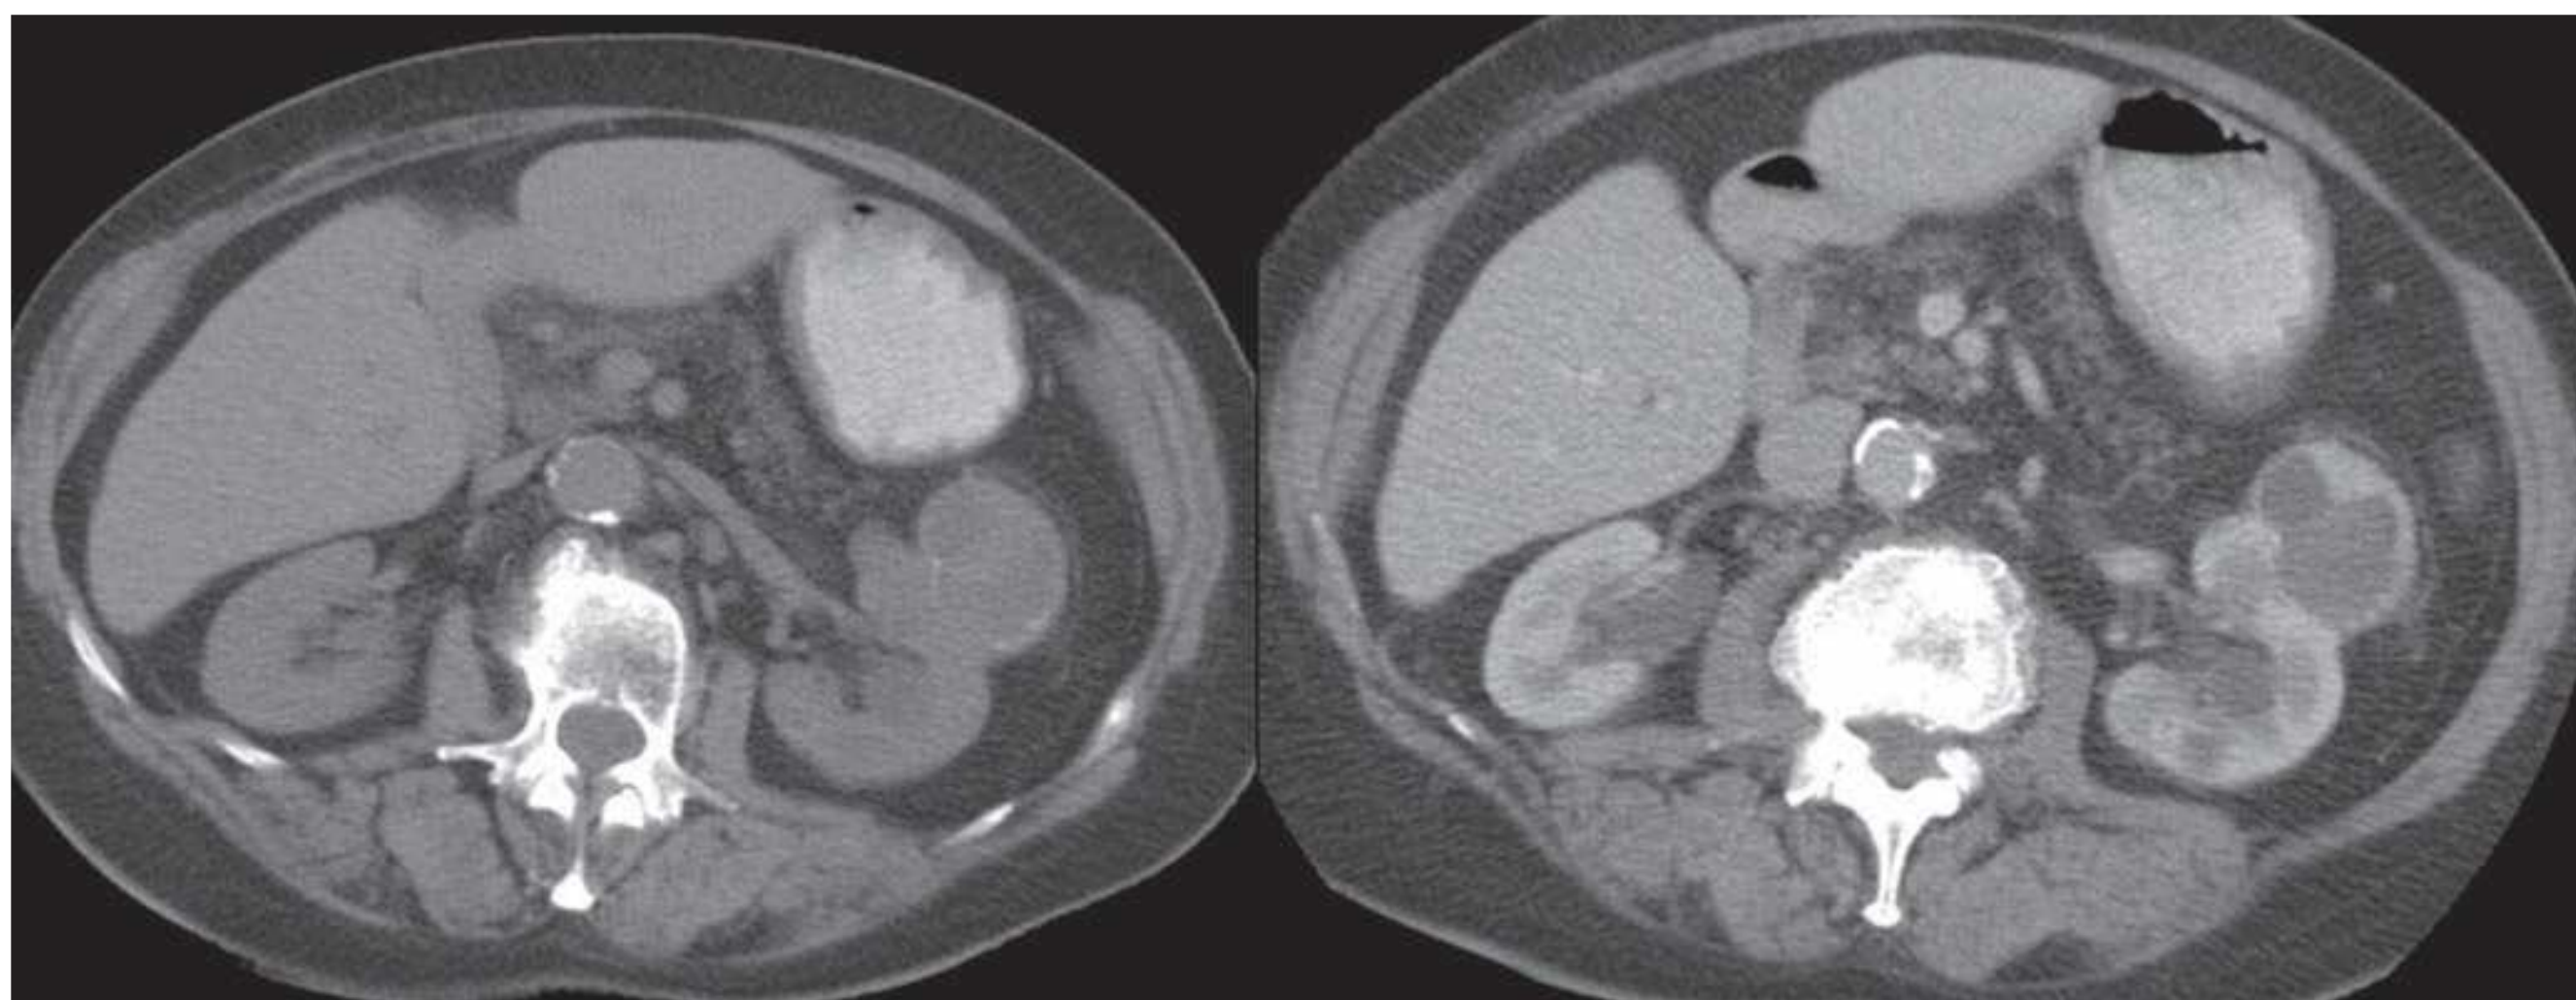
Pre- and post-contrast CT of Bosniak class IV cyst in the left kidney demonstrating peripheral nodular enhancement.
